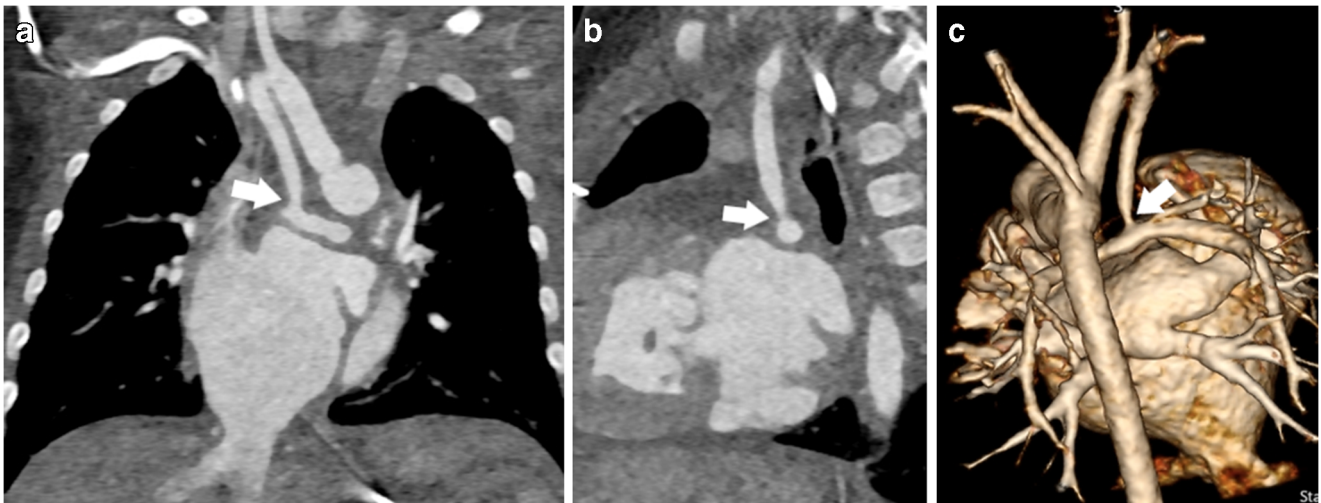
A 2-month-old girl with Blalock-Taussig-Thomas (BTT) shunt stenosis. a–c Coronal (a), sagittal (b) and three-dimensional rendered (c) cardiac CT angiography images show moderate stenosis of the BTT
